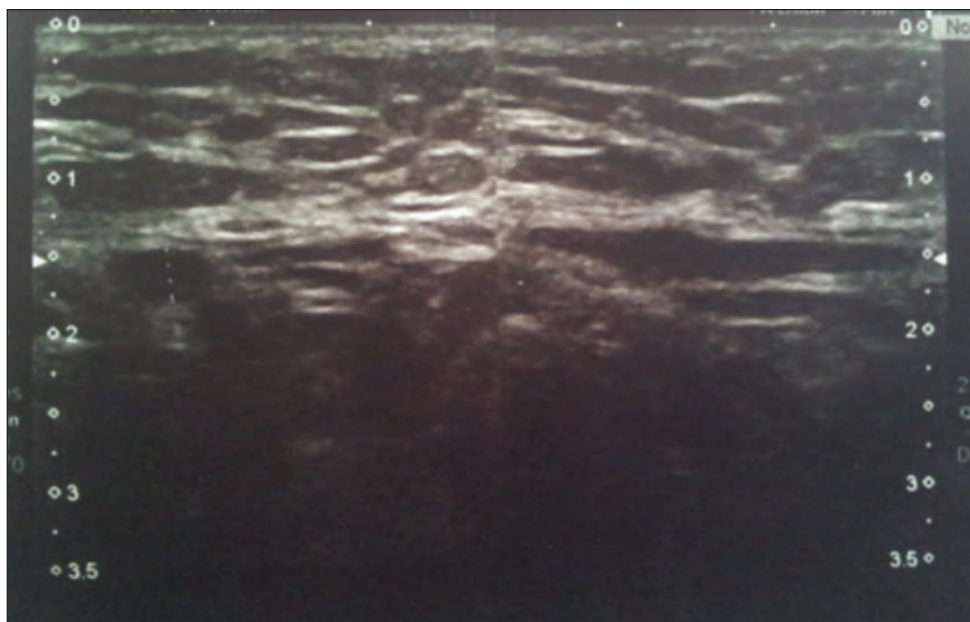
On the third month control Doppler ultrasound, the regression was observed on the size of the thrombosis with an anterior-posterior diameter 3.5 mm and nearly full compression was revealed.
